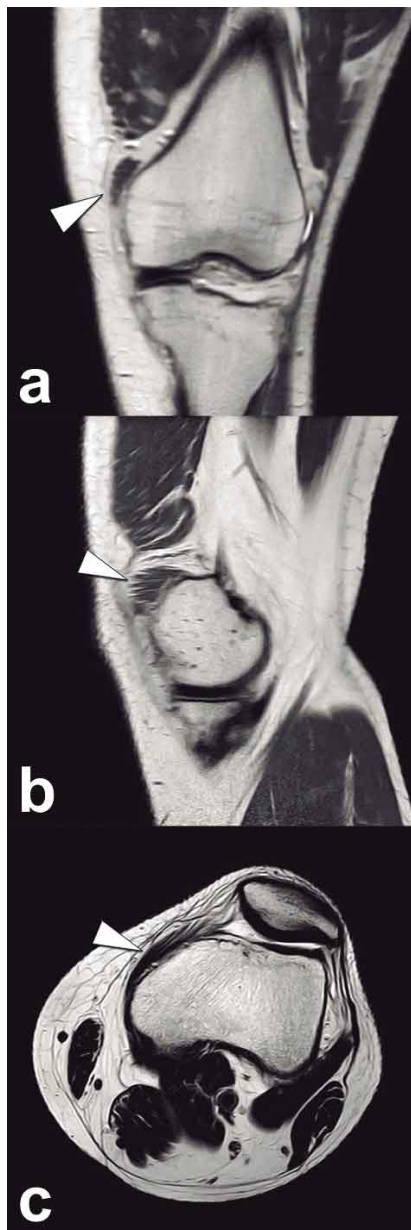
Coronal (a) and sagittal (b) non-saturated proton density-weighted images, and axial T2-weighted image (c) show a multifibrillar structure, isointense to muscle in all sequences, in the expected location of the medial patellofemoral ligament, compatible with a supernumerary medial patellofemoral muscle.
